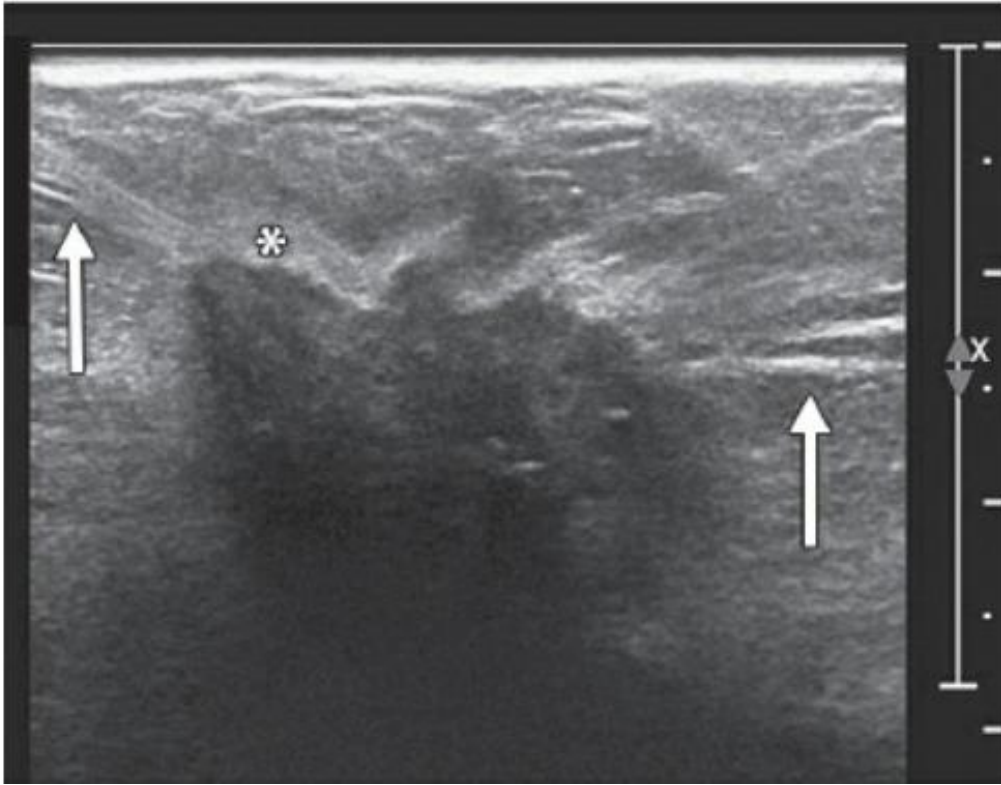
Ultrasound of the breast showing spiculation (*).
